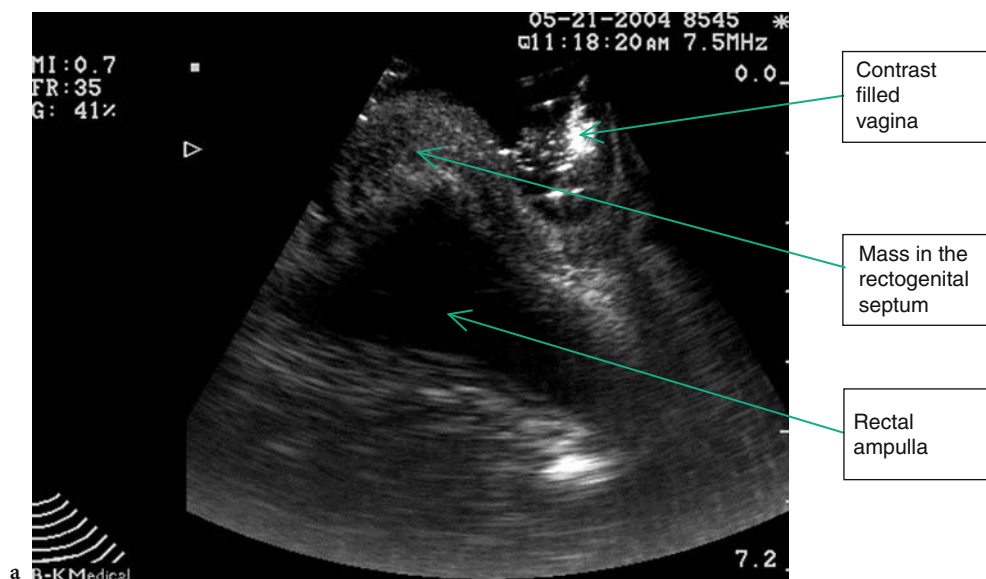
Transperineal ultrasound of a patient presenting with defecation block showing a mass in the rectovaginal septum. This was a recurrence of an anal canal squamous cell carcinoma following initial chemoradiation (a). T1-weighted sagittal magnetic resonance image of the mass (b)
